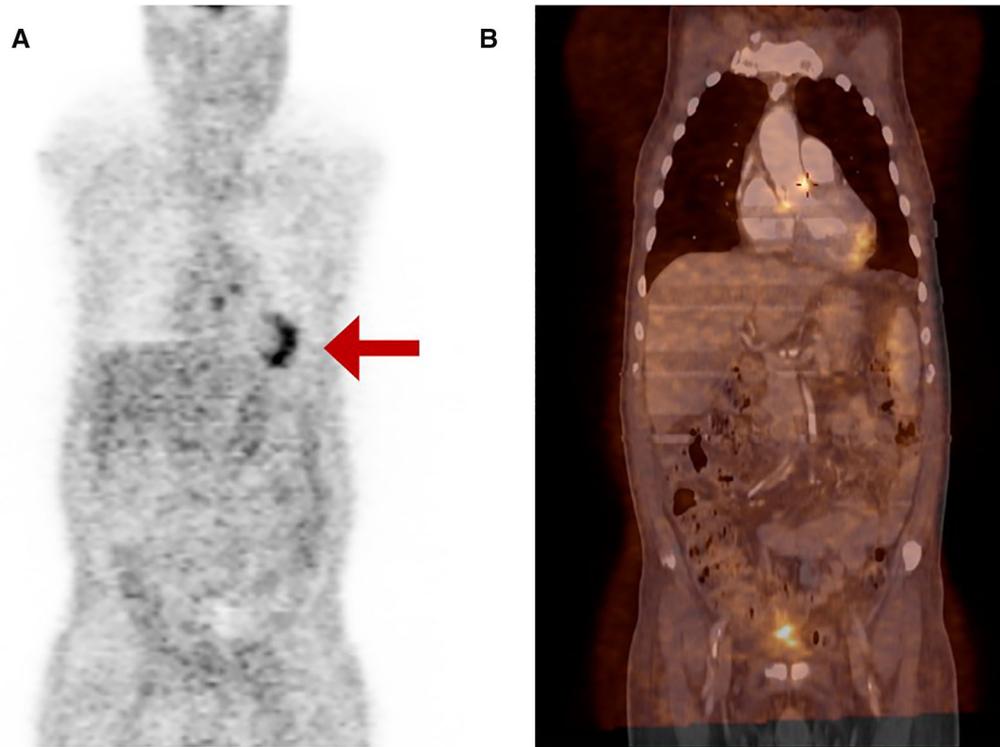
(A) ^{18}F -FDG PET images. (B) PET-CT images. CT scan showed a subendocardial hypodense lesion affecting circumferentially the entire apical cap of the left ventricle, associated with dilatation of the tip that suggests a certain degree of ventricular remodeling, all suggestive of myocardial infarction, which in PET study was represented with increased uptake in the apex ($\text{SUV}_{\text{max}} = 8.3 \text{ g/ml}$) (Red arrow).
